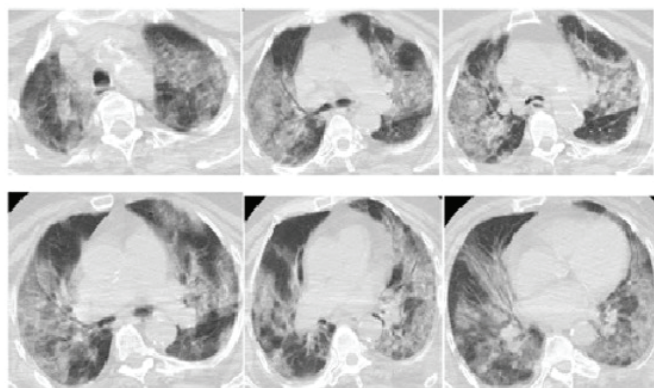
Thorax CT on the 2nd day of the patient's admission to the intensive care unit, and the 5th day of hospitalization. Thorax CT showed bilateral, diffuse ground glass areas, alveolar consolidation, and air bronchograms
